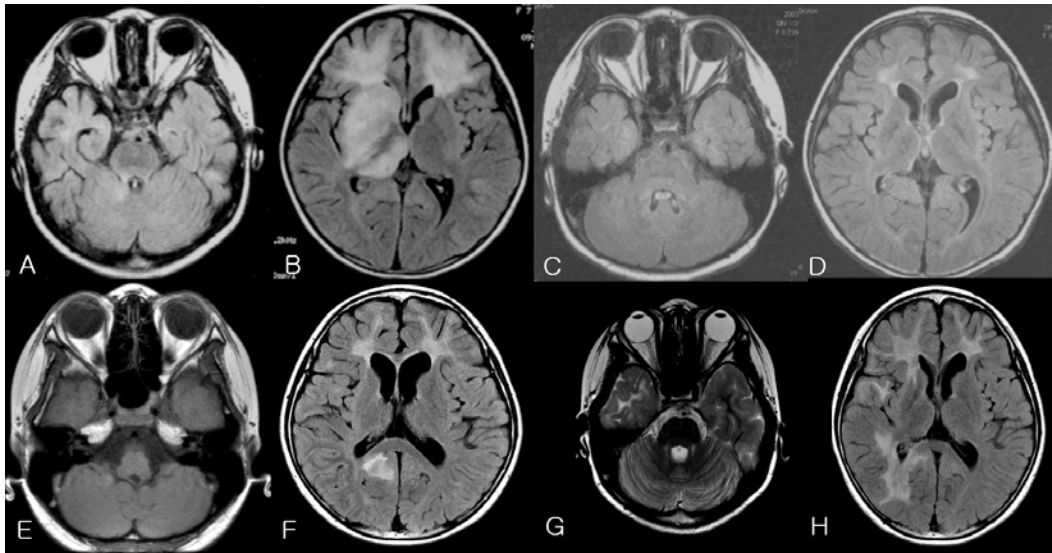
The brain MRI showed multifocal nodular and patchy infiltrations with meningeal enhancement in both frontal lobes and the right basal ganglia area at the 1st attack (A, B). The brain MRI 6 months later after the 2nd attack showed improvement except for both frontal lobes (C, D), and the brain MRI after the 3rd attack 38 months later showed optic nerve atrophy and new right occipital area lesion (E, F). The 4th attack showed left optic nerve swelling and patch infiltration on both the frontal and right parieto-occipital lobes 40 months later (G, H).
